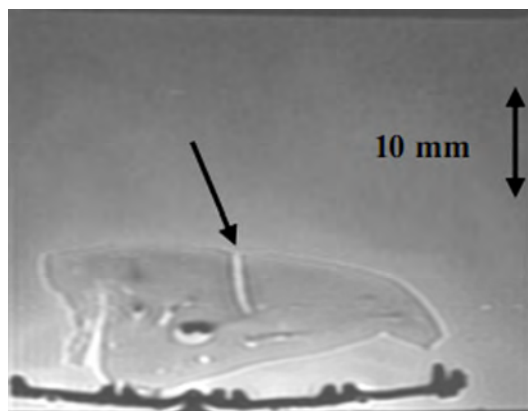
MR image using proton density of lesion in liver created under the influence of boiling. The lesion was created using low intensity (1000 W/cm^2) for long time (30 s).
